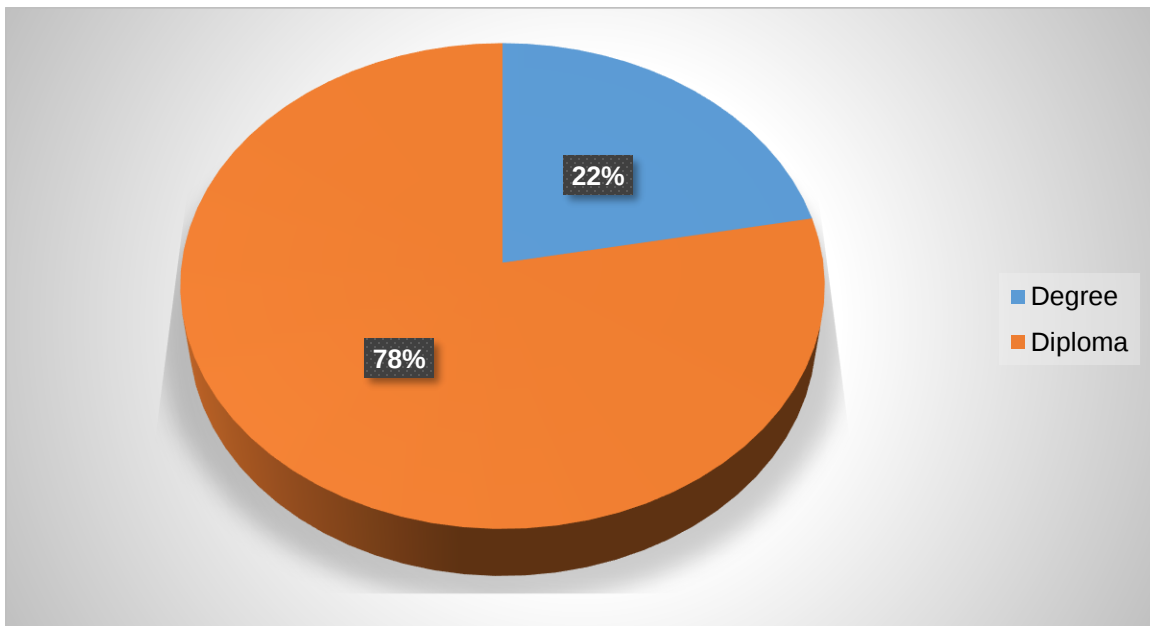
Professional qualifications of radiographers (n = 27)
